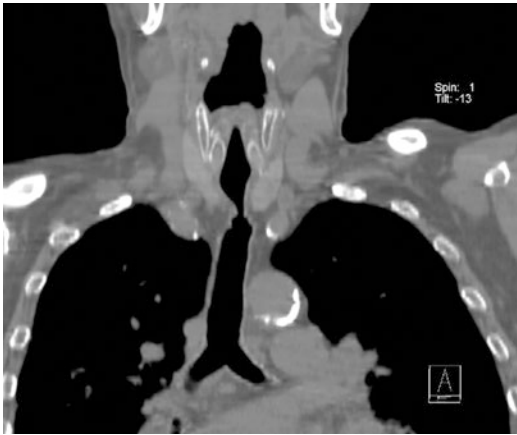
Coronal CT image of benign tracheal stenosis
